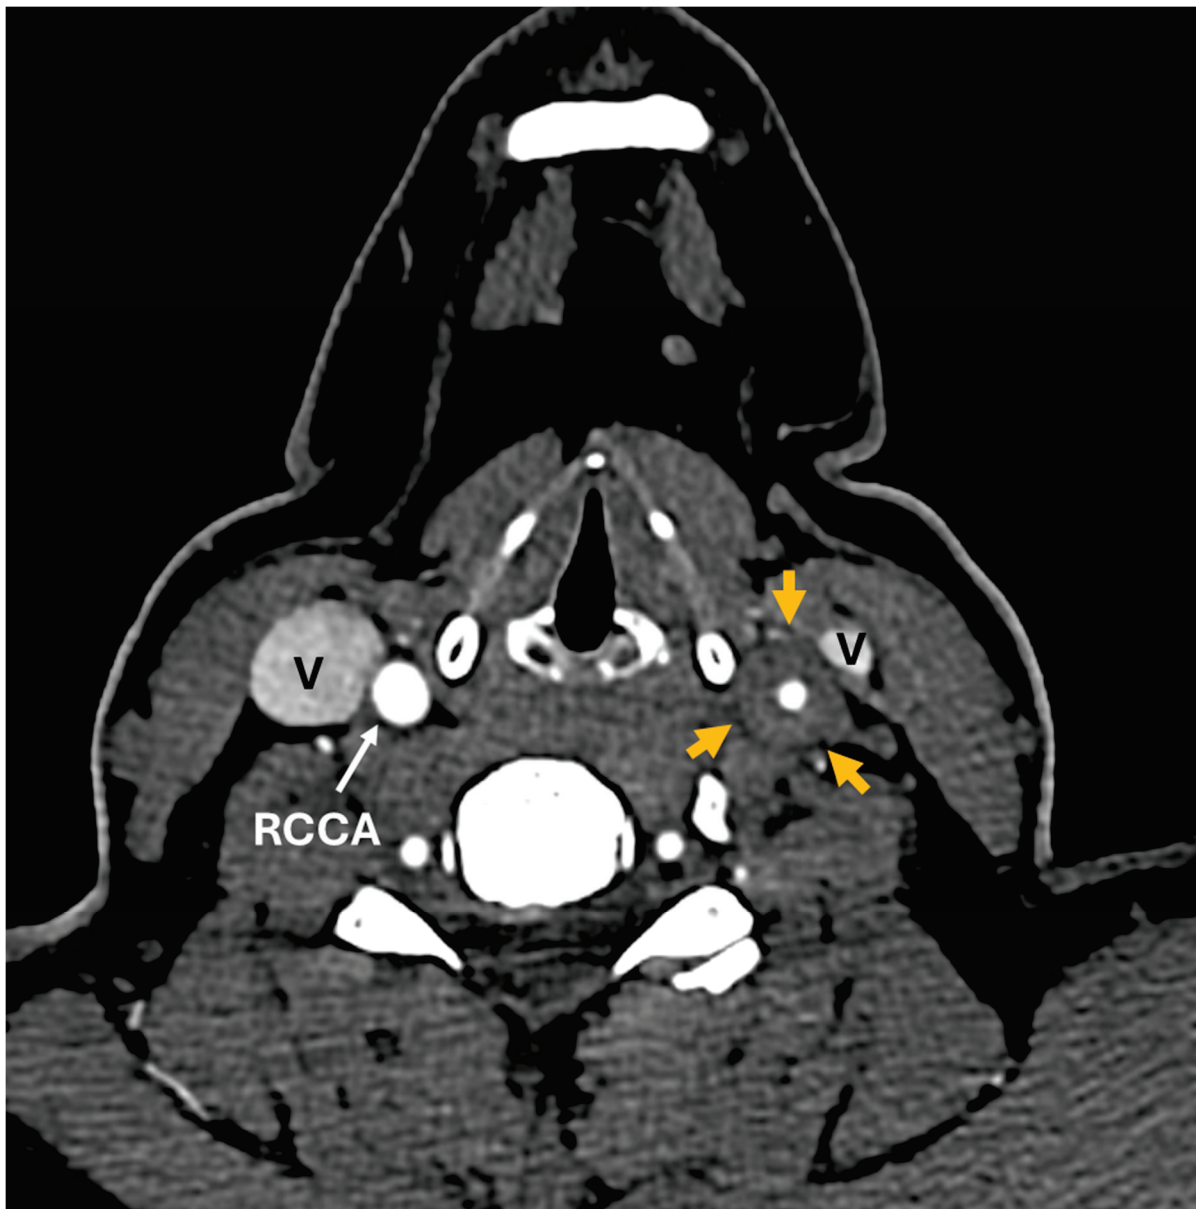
CT angiogram. Axial images below the level of carotid bifurcation show diffuse circumferential thickening of common carotid artery (CCA) and internal carotid artery (ICA) walls on the left side (orange arrows).
